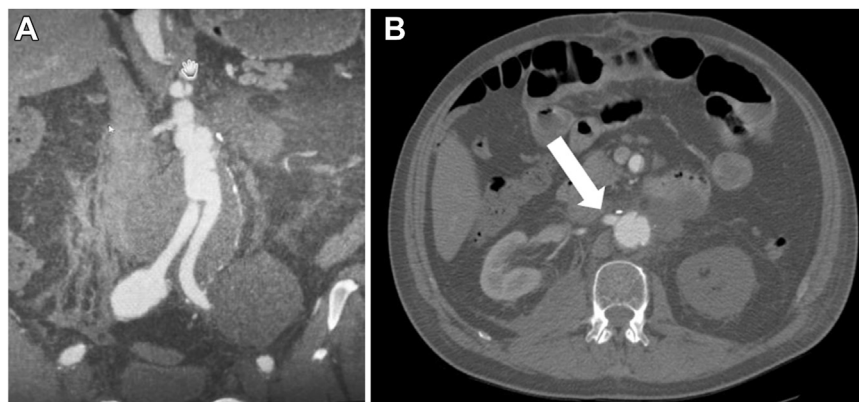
Postoperative computed tomography (CT) image of aorta after removal of the AFX stent graft and implantation of a bifurcated Dacron graft (A), with reperfusion of the right kidney artery (B).
